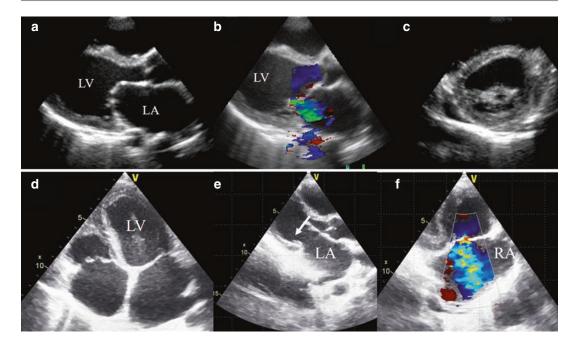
Echocardiography is a versatile tool for identifying cardiac structural disorders in patients with heart failure. Panel a–c show echocardiographic findings in a patient with rheumatic mitral valve disease with severe left ventricular systolic dysfunction resulting from an underlying rheumatic carditis. Panel d–f show echocardiographic findings in a patient with heart failure resulting
